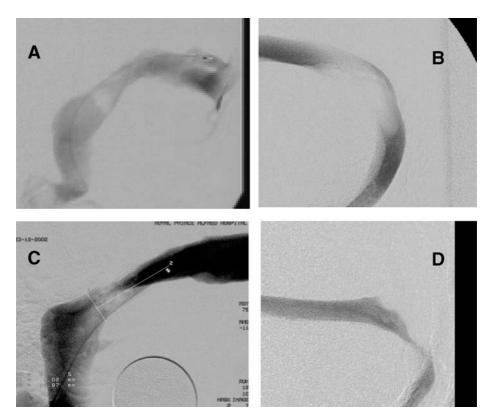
Various forms of focal venous sinus obstruction in the transverse sinuses of 4 patients. Intrinsic filling defects are obvious in the top two radiographs being an arachnoid granulation (A) and a broad based undulating lesion (B). Of the lower two, the radiograph on the left (C) could be a focal stricture or extrinsic compression while the radiograph on the right (D) appears to indicate secondary venous sinus compression or irregularity due to old thrombus
